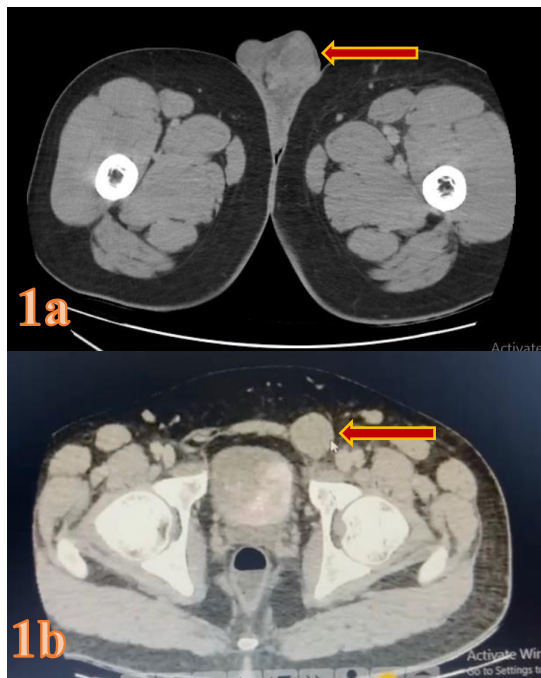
CT image- the left testicular mass, and 1b. extension of the mass into the left inguinal canal.
